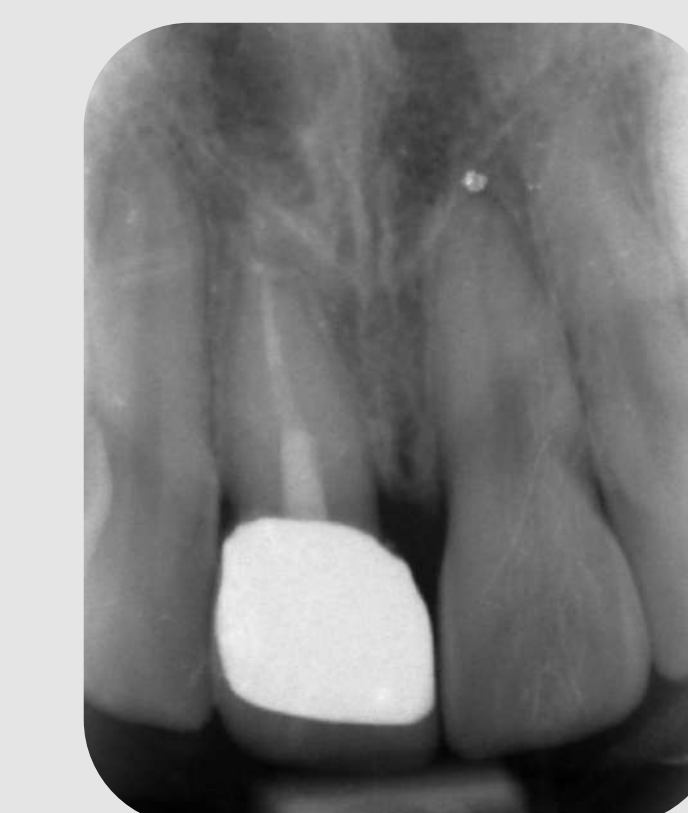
1 year follow-up: periapical radiograph
